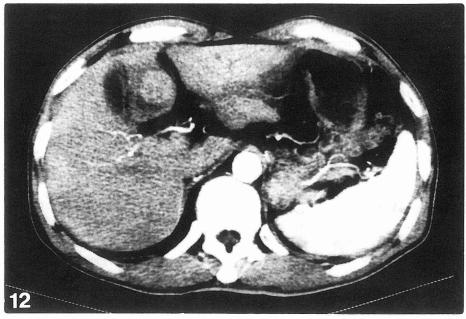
CT of one Japanese case of spontaneous rupture of HCC. One nodular tumor accompanied by fluid accumulation in the medial segment, similar to that in Case 3, was detected. In this case, liquid accumulation also disappeared at surgery.
